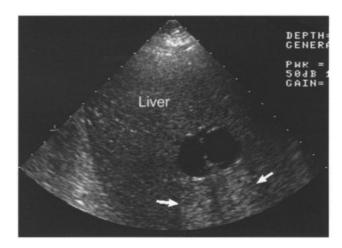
Ultrasonography: A septated, round, unechoic area, 4-5 cm in diameter can be seen in the liver parenchyma, with relative enhancement (arrows) behind it.
